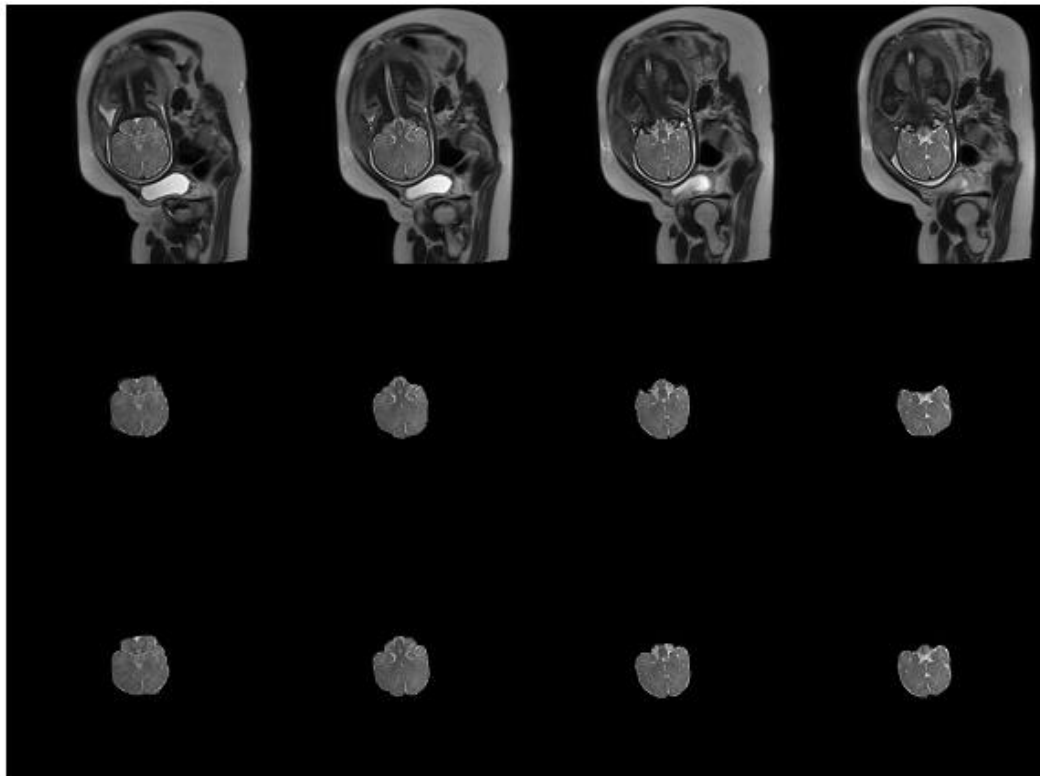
Axial view of a segmented fetal brain obtained via MRI scan. Row 1 presents original images, row 2 presents manual segmentation and row 3 present proposed result.
